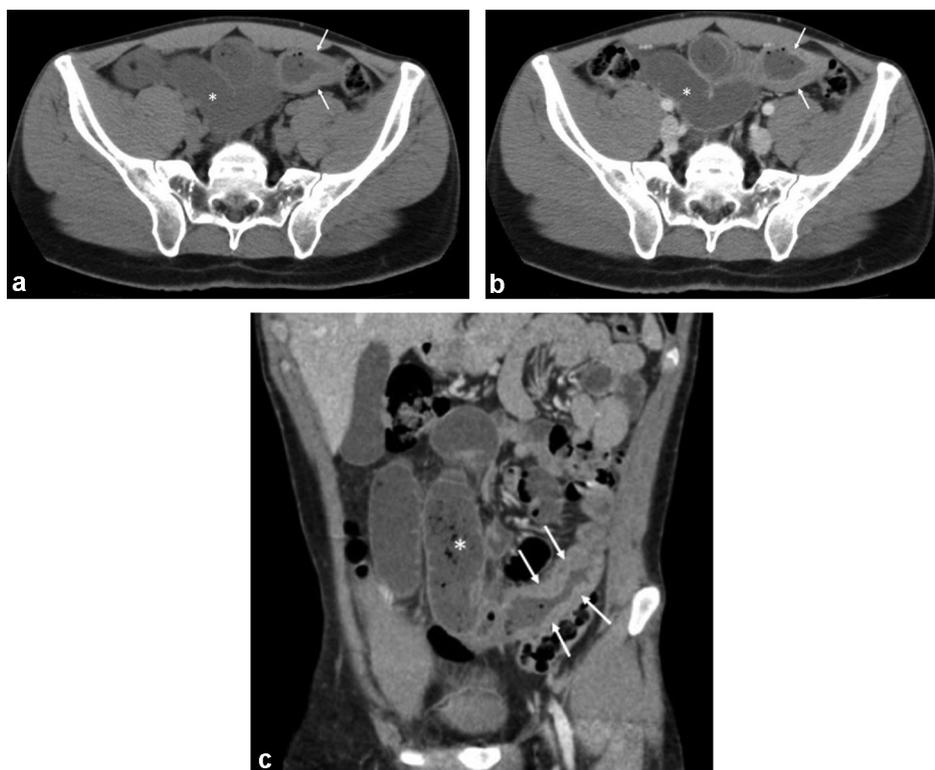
26-year-old man with severe hemophilia B presenting with acute intestinal obstruction after a large meal. Unenhanced abdominal CT (A) and contrast-enhanced abdominal CT images in the transverse (B) and coronal (C) plane show hyperattenuating circumferential thickening of the small bowel wall due to intramural hematoma (arrows) and dilated bowel (asterisks) due to mechanical obstruction. This patient had repeat similar episode two years later.
